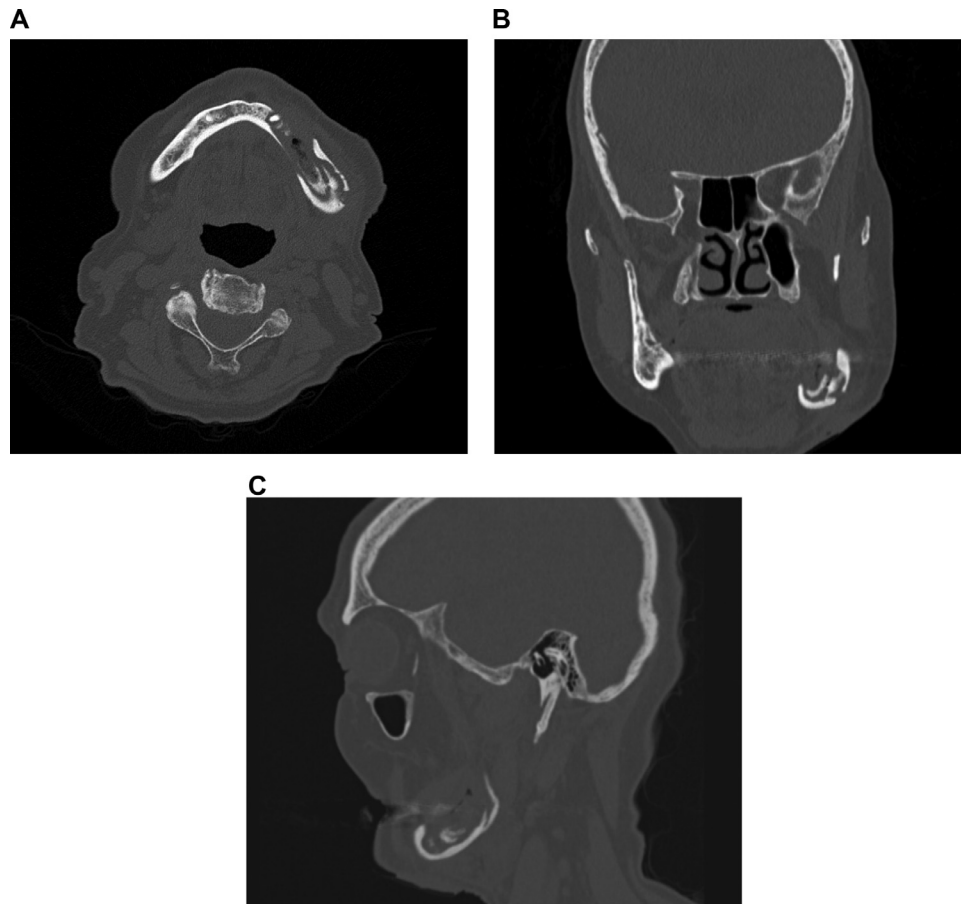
Preoperative computed tomography (CT) scan before a continuity resection and reconstruction with a free fibula flap. A, Coronal plane. B, Axial plane. C, Angulated view of the sagittal plane.
